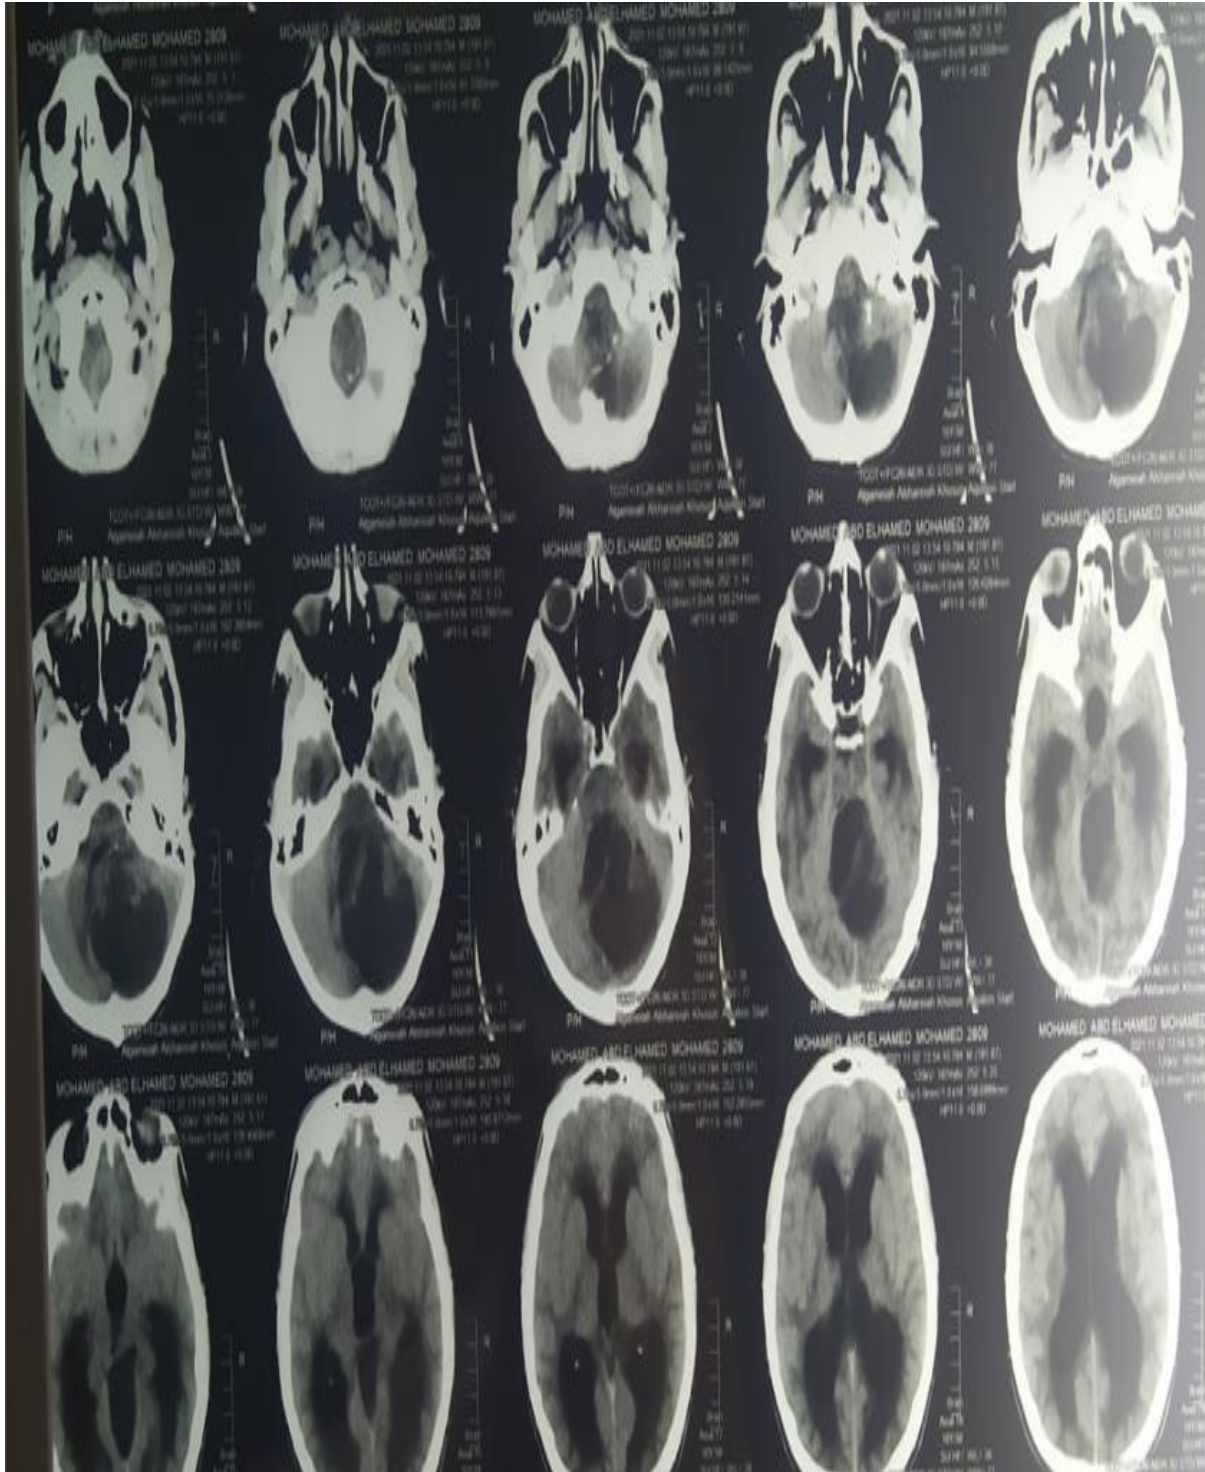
Preoperative CT brain without contrast, axial view.
